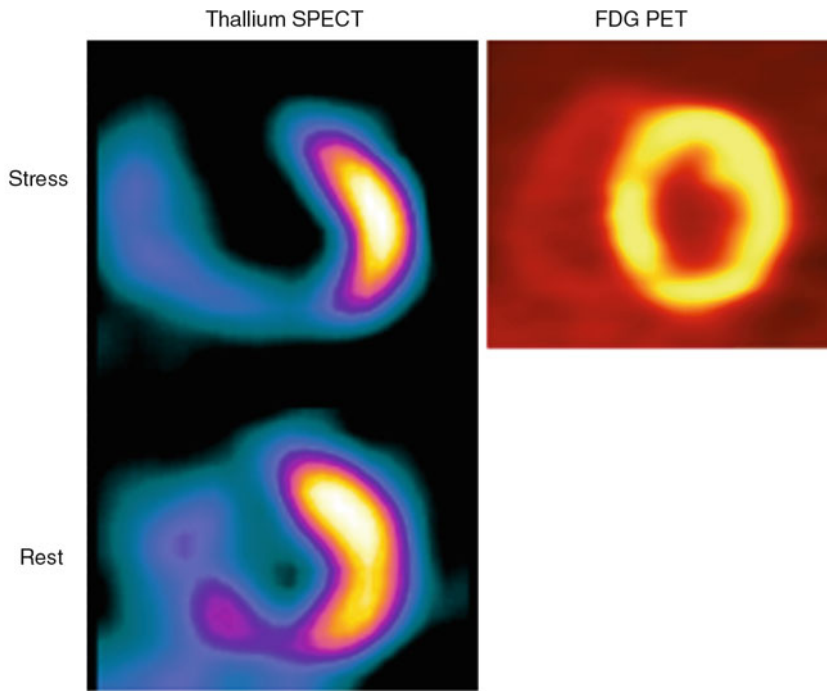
Thallium-201 and ^{18}F -FDG PET images of viable myocardium. Severe perfusion decrease was noted on anterior, septum, and inferior wall on short axis of thallium SPECT. However FDG uptake was preserved on corresponding areas, suggestive of viable myocardium
